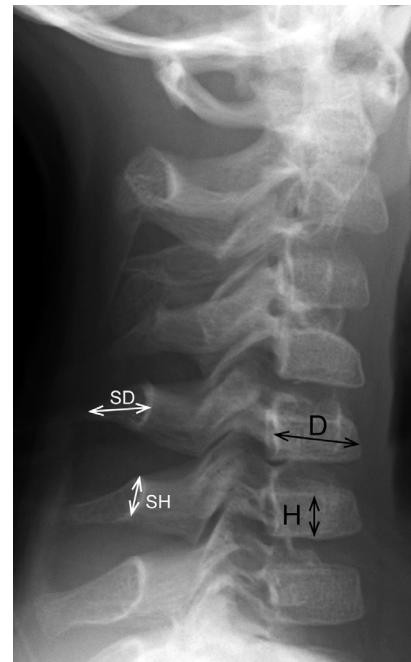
A radiograph depicting the measurements of the bone length in the cervical spine. The height (H) and depth (D) of the C5 vertebral body was measured at the midpoint of the body. The height of the C5 spinous process (SH) was defined as the distance from the cranial to the caudal rim at the juxta-laminar zone. The depth of the spinous process (SD) was measured from the midpoint of the anterior wall to that of the posterior rim.
